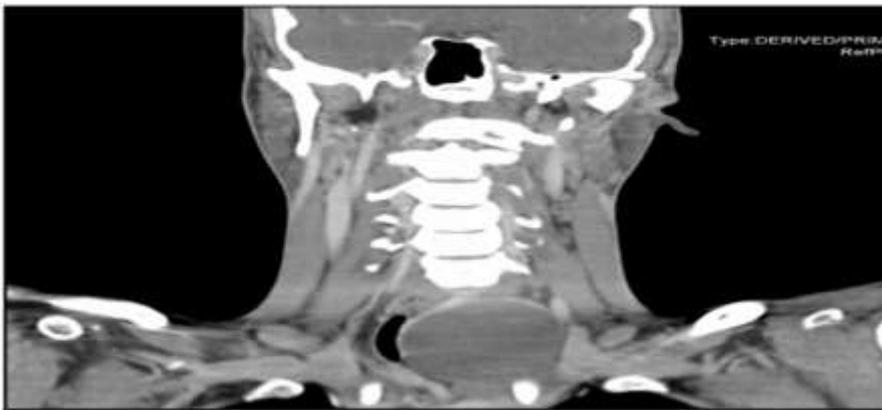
Axial view of trachea stricture and thyroid cyst in first CT scan.
